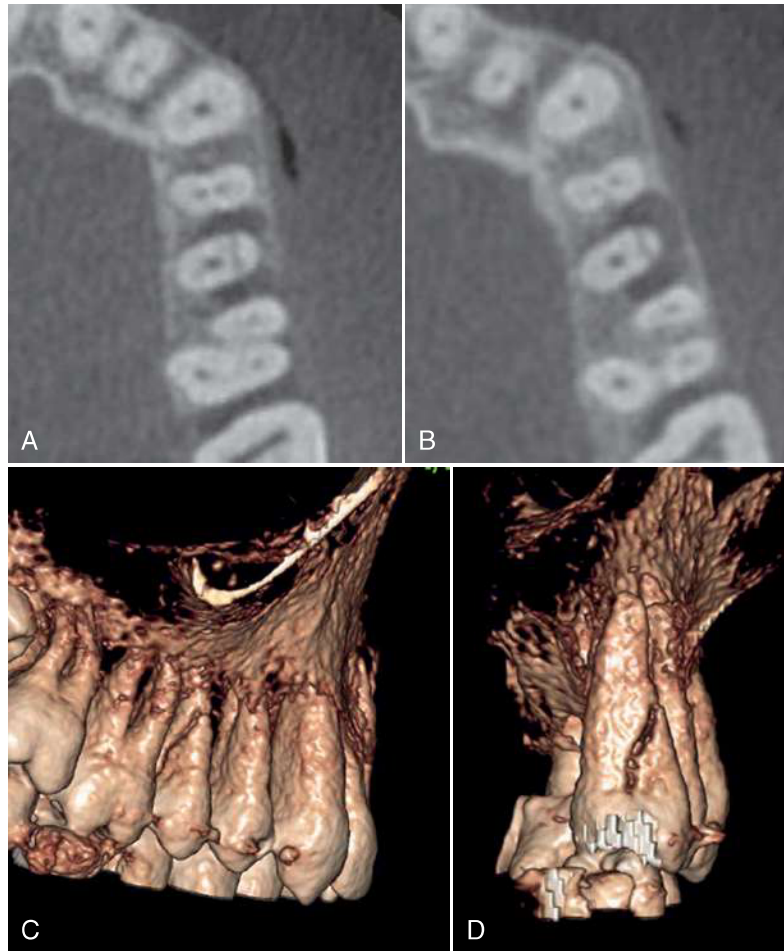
Diagonally split tooth. A maxillary right second premolar presented with a mesiodistal coronal fracture. A, B, CBCT axial views revealing a mesiodistal fracture at two different levels, with associated mesial and distal bone loss. The more coronal view has mesial and buccal bone loss (A). A more apical view reveals mesial, distal, and buccal bone loss (B). C, D, the three-dimensional reconstruction clearly reveals the nature and direction of the fracture and defined the tooth as unrestorable. Both bone loss and the thick dimensions of the fracture line indicate a longstanding case in which bone resorption allowed opening of the fracture to dimensions that could be detected by CBCT. It is unlikely that such clear demonstration of the fracture line could appear at earlier stages of its formation. (Courtesy Dr. Anda Kfir, Tel Aviv, Israel.)
